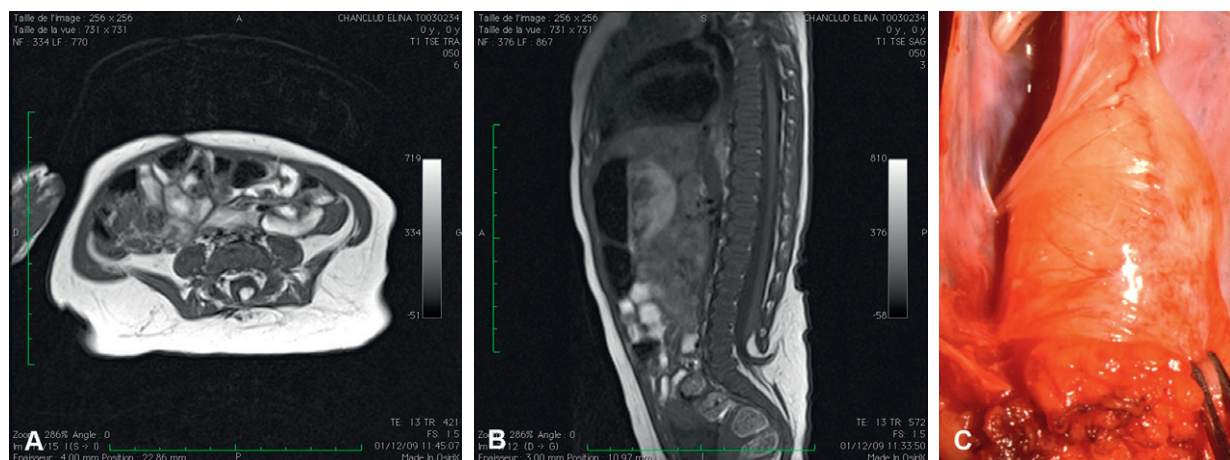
Lipoma of the conus. (A) T1-weighted axial MR; (B) T1-weighted sagittal MR; (C) Surgical view.
